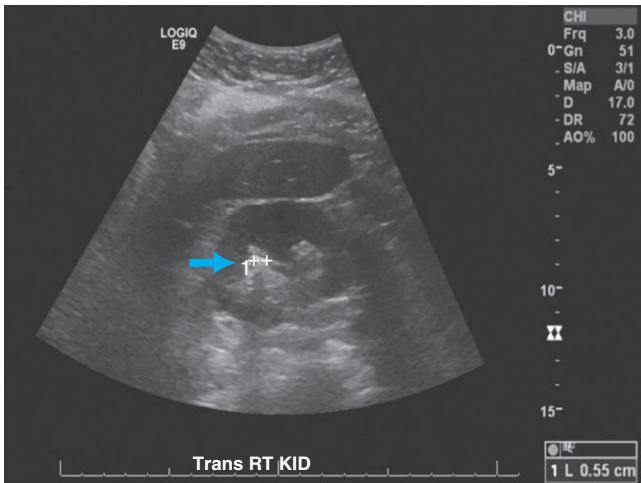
Gray scale ultrasound image demonstrates an echogenic focus with posterior acoustic shadowing (arrow).
